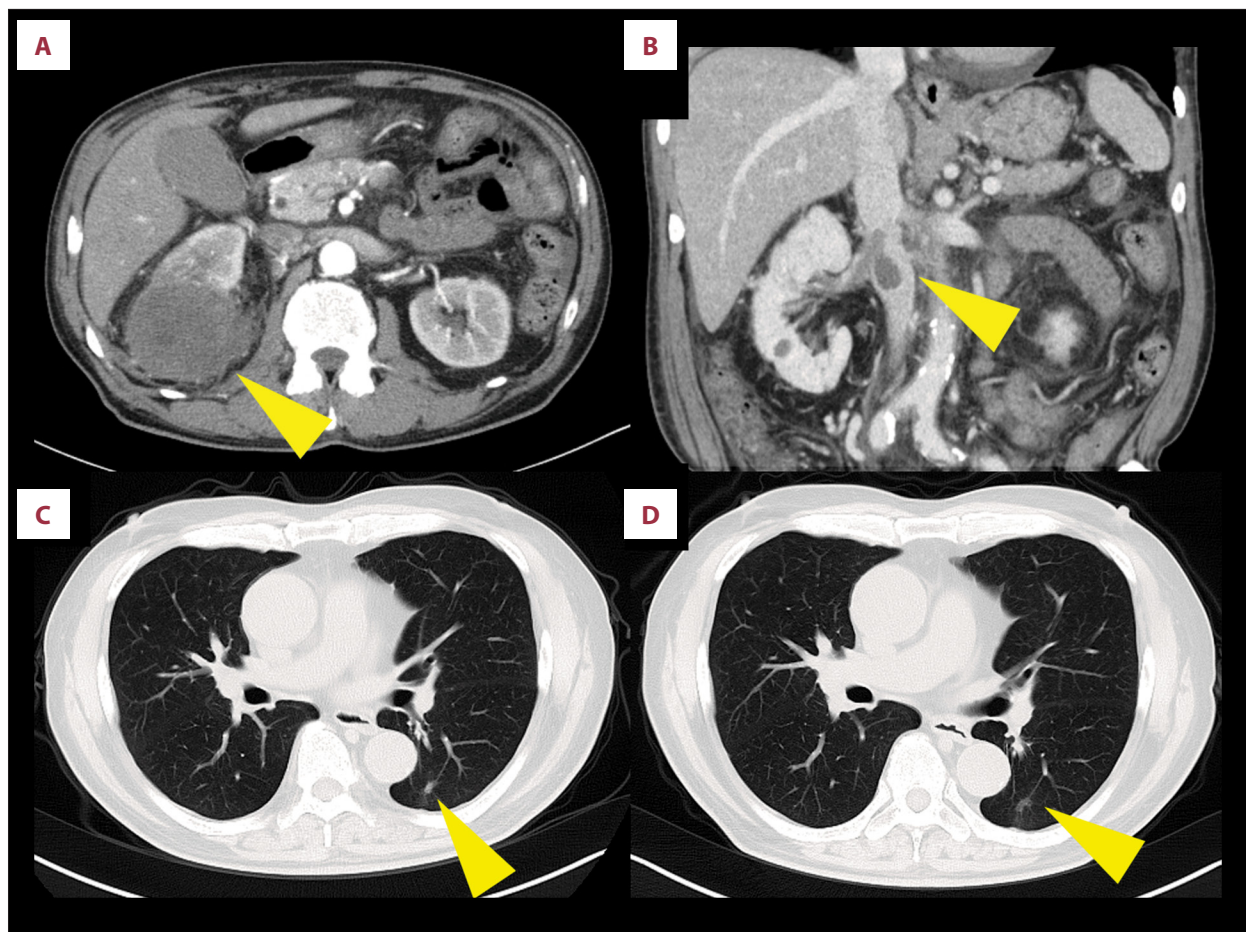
Radiological response after lenvatinib plus pembrolizumab and complete extracranial response after deferred cytoreductive nephrectomy. (A) Contrast-enhanced computed tomography (CT) after systemic therapy showing marked reduction of the right renal tumor (arrow). (B) Coronal CT image after systemic therapy showing shrinkage of the inferior vena cava (IVC) tumor thrombus (arrow). (C) Chest CT after systemic therapy showing near-complete resolution of pulmonary metastases (arrows). (D) Follow-up chest CT after deferred cytoreductive nephrectomy showing disappearance of pulmonary metastases, consistent with complete response (CR).
